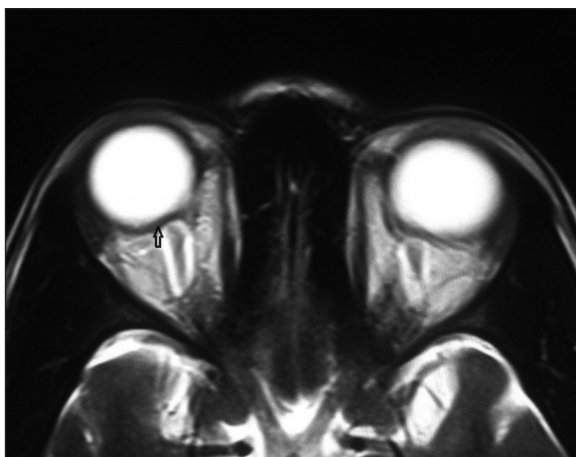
MRI showing flattening of posterior globe
